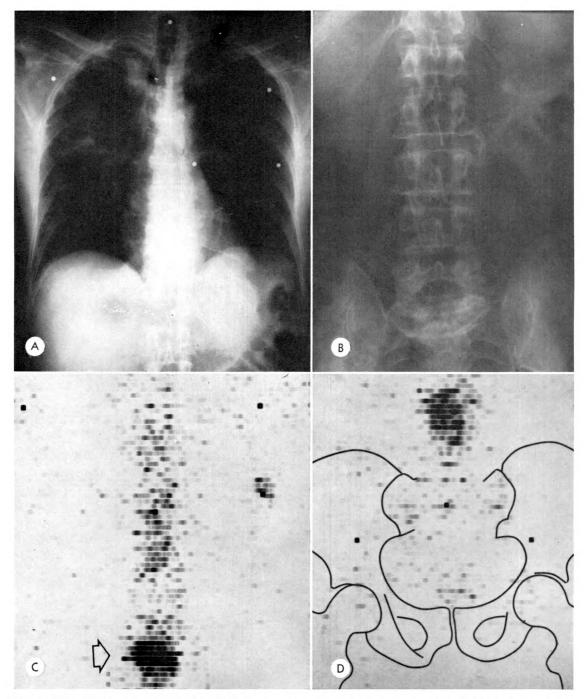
This elderly male developed multiple bone metastases to the dorsal spine and ribs from an anaplastic carcinoma of the lung (A). His chief complaint was low back pain. (B) Roentgenogram of lumbar spine shows osteoarthritic changes and compression of L-I. (C and D) The strontium scans, in addition to showing numerous areas of abnormal uptake in the dorsal spine, rib, and in L-I (arrow in C) revealed activity in L-3 and -4 as well, despite negative roentgenographic findings in this area. Radiation therapy to the lumbar spine relieved the patient's pain. This case shows the value of the strontium bone scan in determining the extent of metastatic disease.
